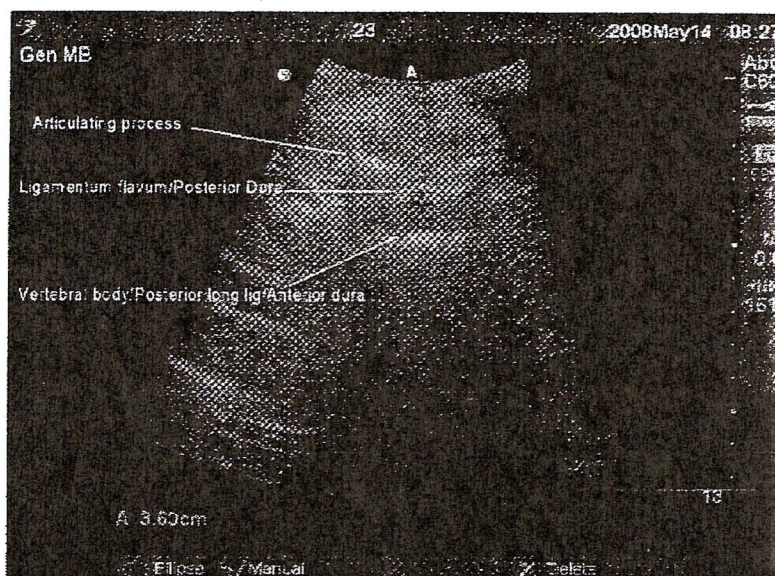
Transverse ultrasound plane.
